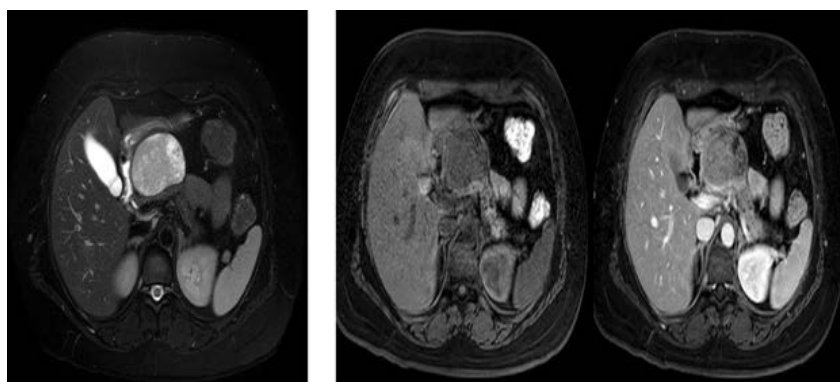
Lesion located at the neck of the pancreas with a dimensions of 68x44x56 mm with cystic areas in T2-weighted series, thick walled straight contrast mass lesion with heterogencontrast attachment in T1 weight series.
